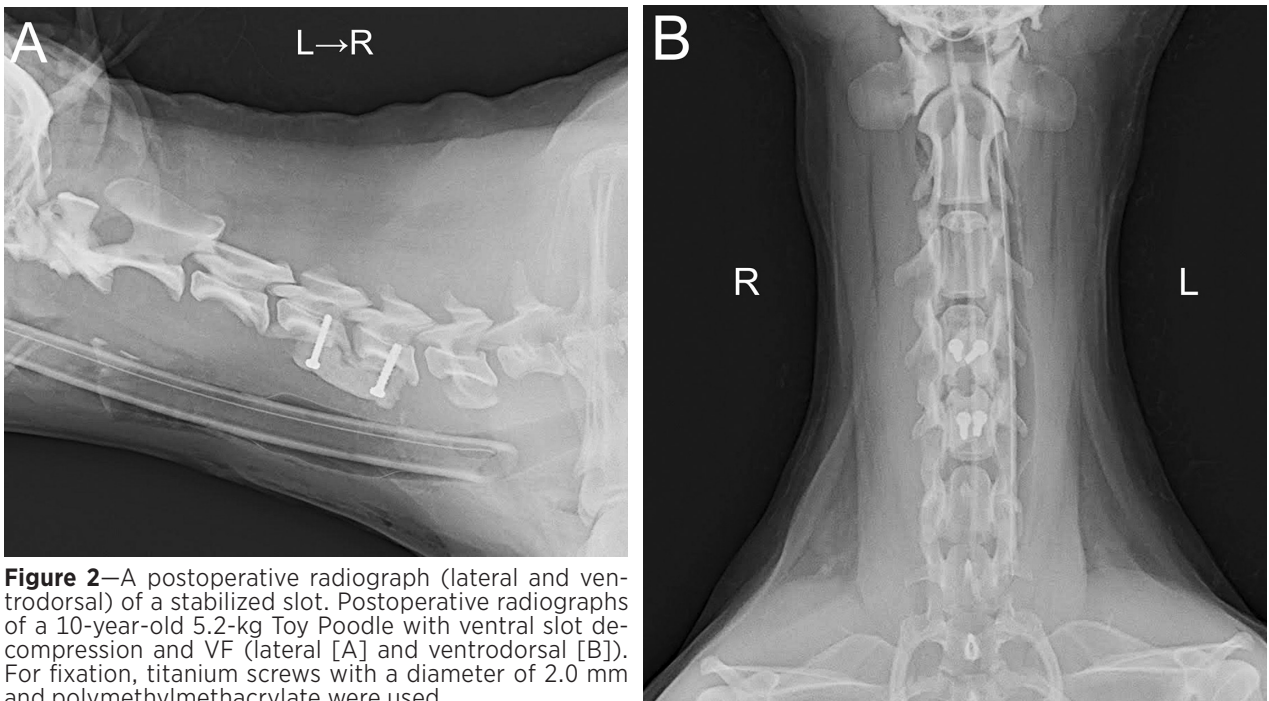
A postoperative radiograph (lateral and ventrodorsal) of a stabilized slot. Postoperative radiographs of a 10-year-old 5.2-kg Toy Poodle with ventral slot decompression and VF (lateral [A] and ventrodorsal [B]). For fixation, titanium screws with a diameter of 2.0 mm and polymethylmethacrylate were used.
